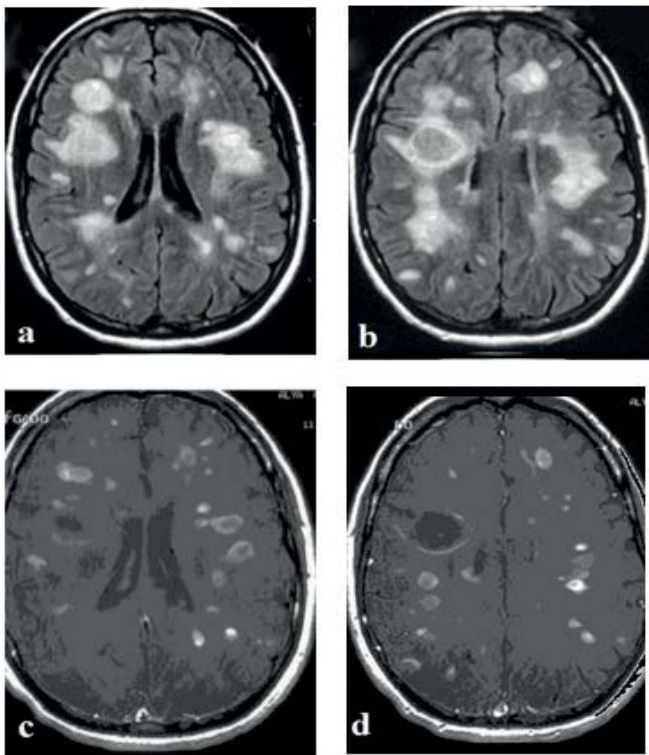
Brain MRI (04/2011): Axial fluid-attenuated inversion recovery (FLAIR) (a,b) and post contrast T1 weighted (c,d) images of hyperintense and oval lesions in the periventricular, sub-cortical and corpus callosum structures with the largest in the right frontal lobe. Measuring 3 cm in diameter and annular enhancement of most lesions.
